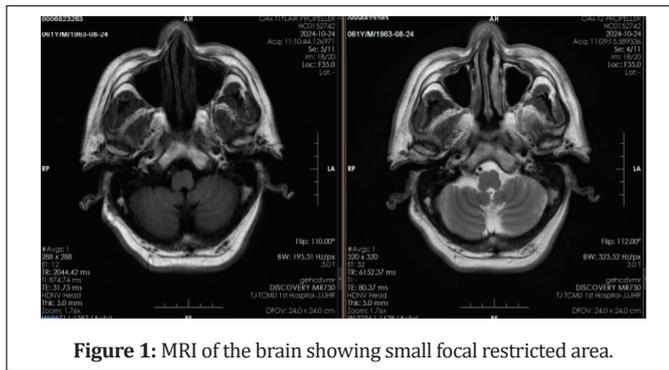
MRI of the brain showing small focal restricted area.
